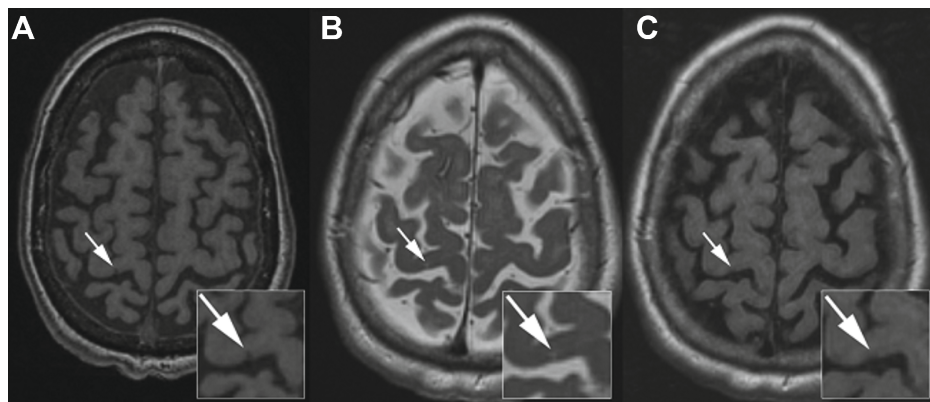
Example of a cortical microinfarct, seen as a hypointensity on T1-weighted (A), hyperintensity on T2-weighted (B) and isointensity on FLAIR (C) image.
